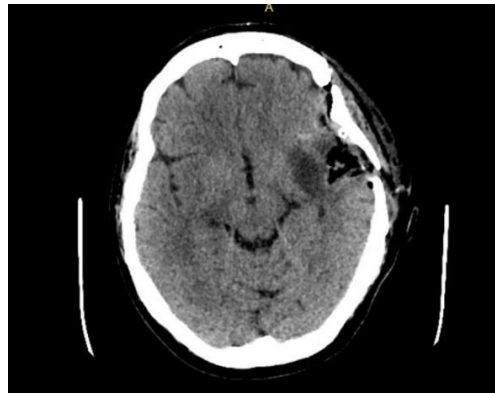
The CT images from 2023 present postoperative aspects corresponding to the second surgical intervention
